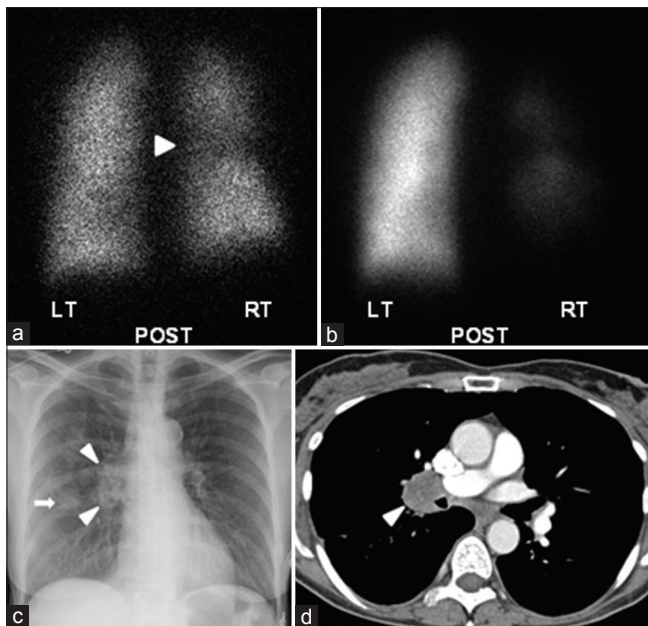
Right hilar malignant tumor. (a) Ventilation image showing a small ventilation defect in the right hilum (arrowhead); ventilation is otherwise preserved. (b) Perfusion image showing severely decreased perfusion to the entire right lung. (c) Chest radiograph showing a right hilar mass (arrowheads) and a round parenchymal nodule in the right midlung (arrow). (d) Axial contrast-enhanced computed tomography image showing a right hilar mass (arrowhead). LT indicates left; POST, posterior; RT, right
